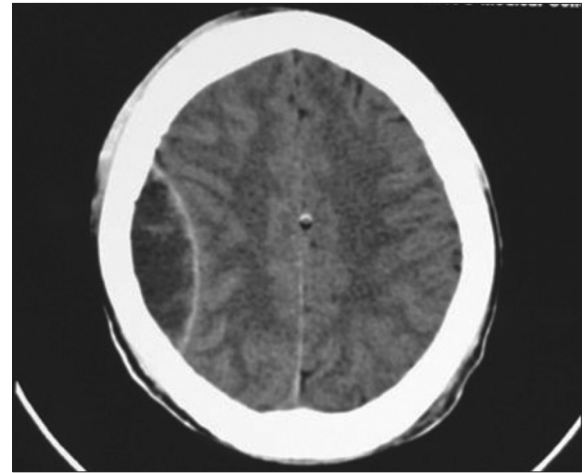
Axial CT scan of head shows Rt parietal heterogeneously hypodense biconvex extradural lesion
